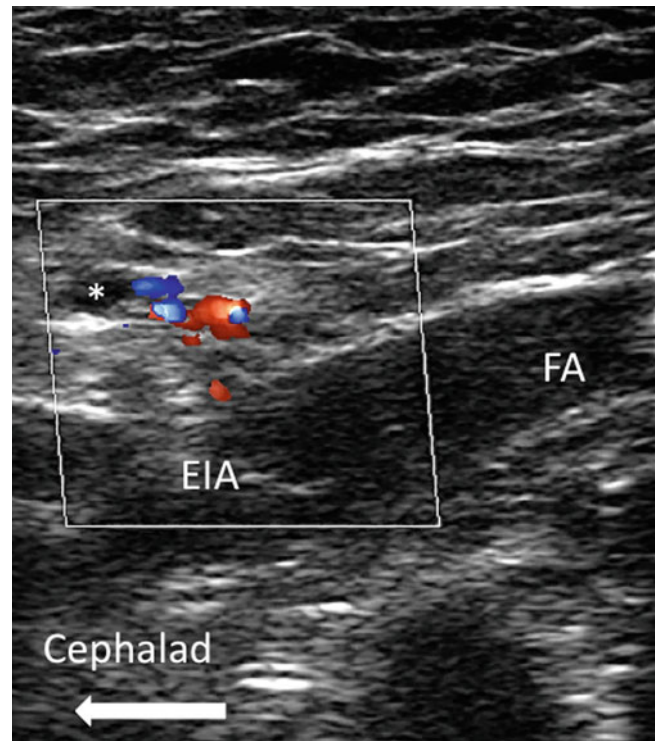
Similar view as in Fig. 54.6 with color Doppler showing the vessels inside the spermatic cord (Reproduced with permission from Philip Peng Educational Series)
